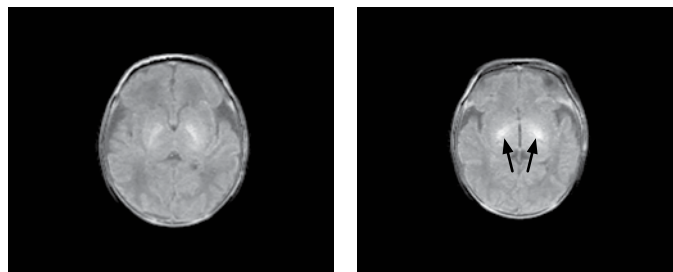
MRI T1-weighted sequence carried out at 7 days of life, presenting with bilateral hyperintensity in the globus pallidus (arrows), suggestive of bilirubin deposits.
